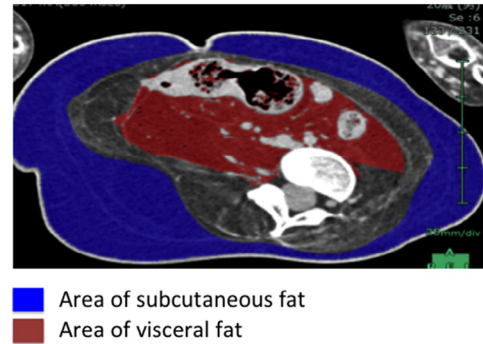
Measurements of subcutaneous fat (blue square) and visceral fat (brown square) volume at the umbilical level by computed tomography.
